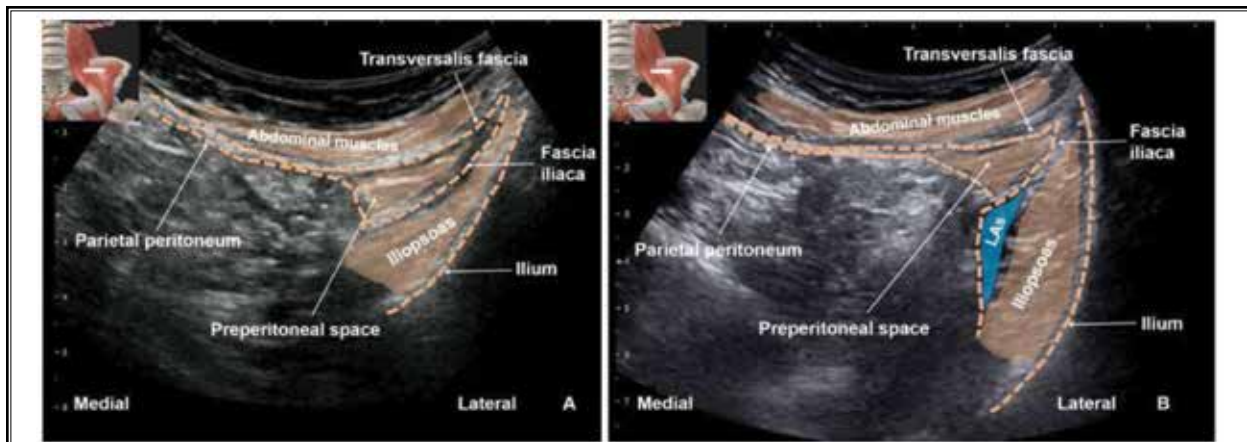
The sonogram of the suprainguinal FICB. (A) The space among the peritoneum, iliac fascia, and TF is called the preperitoneal space, which is mainly filled with fat in adults or obese people. (B) The blue area shows the LAs spreading on the surface of the iliopsoas after the FICB. The fat tissue is easily recognized as the PM muscle when performing the iliopsoas plane block. The inserted image indicates the probe's position.
